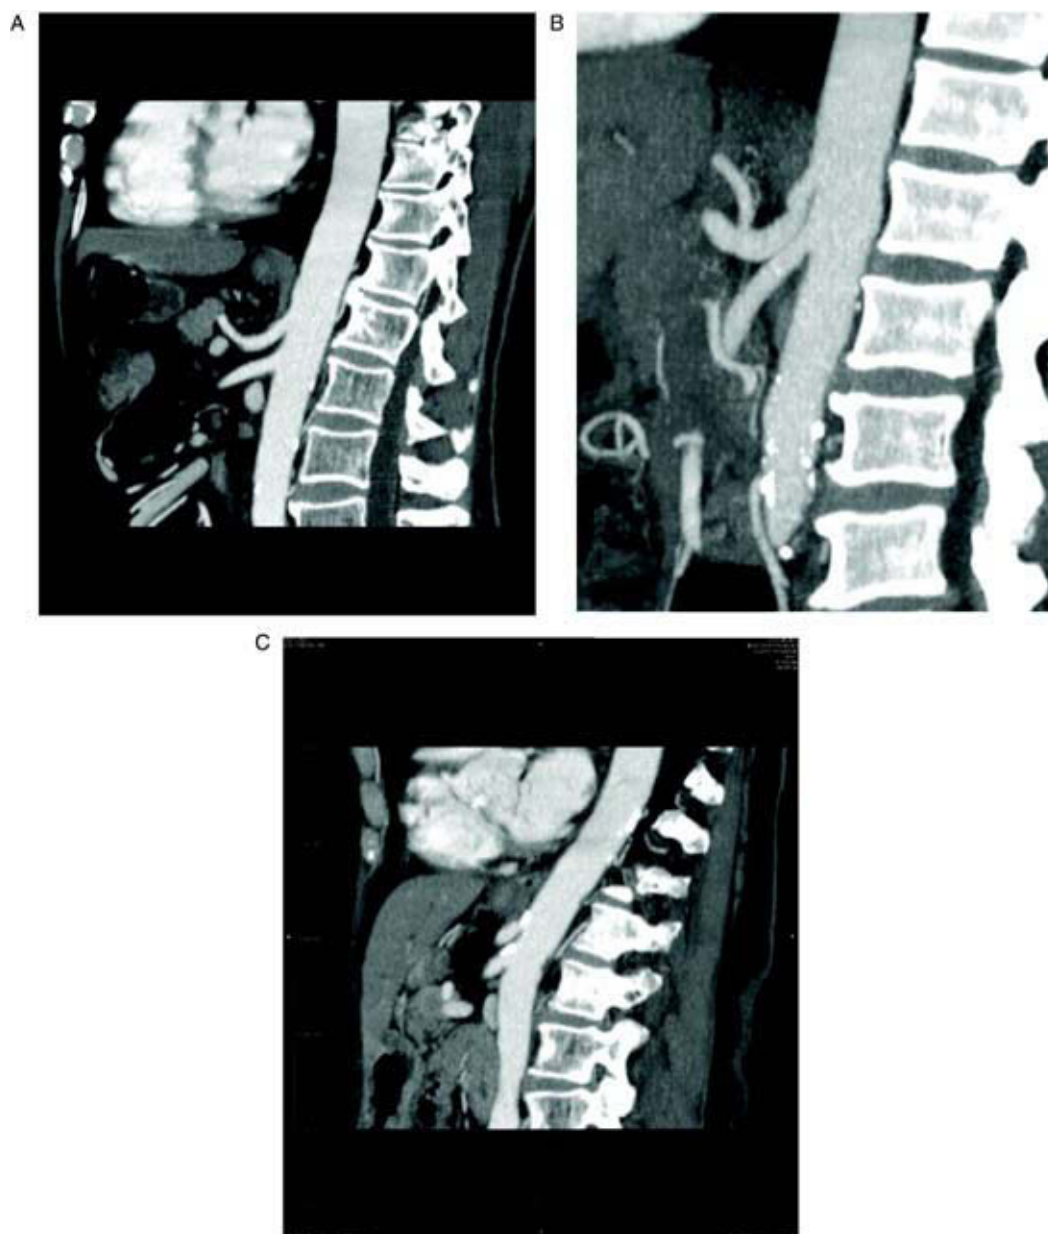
multidetector computed tomography; reconstruction using MIP (maximal intensity projection) technique; sagittal projection of the celiac trunk (CT) and the superior mesenteric artery (SMA). B: stenosis of the CT caused by the arcuate ligament. C: stenosis of the CT and the SMA as a result of atherosclerosis.
